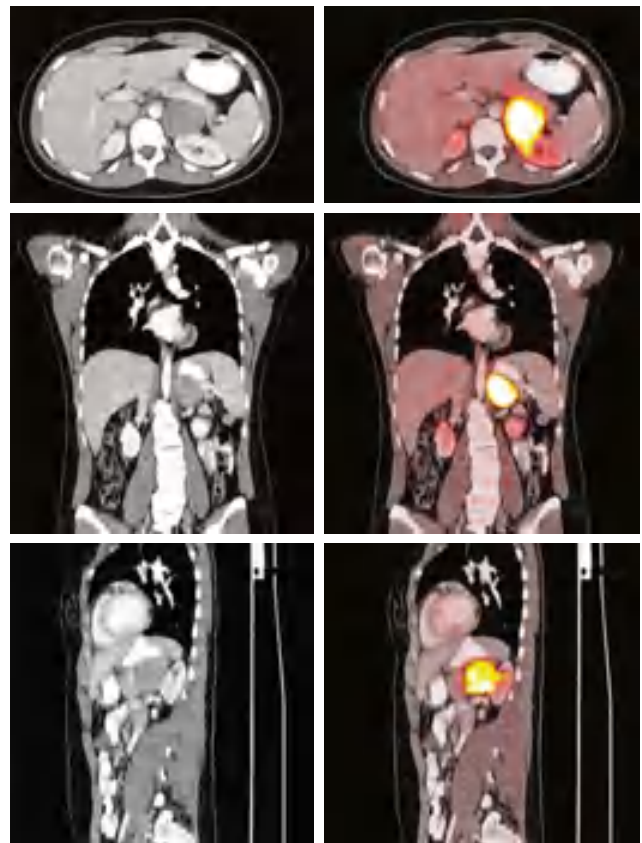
Appearance of pheochromocytoma on functional imaging (^{18}F -l -dihydroxyphenylalanine [^{18}F -DOPA] PET/CT). Focal uptake is seen in the left suprarenal fossa. (From Duh QY, Livhits M, Yeh MW. The adrenal glands. In: Mattox KL, Townsend CM, Beauchamp RD, Evers BM, eds. *Sabiston Textbook of Surgery*. 21st ed. Philadelphia: Elsevier; 2022. Fig. 40.18A.)
